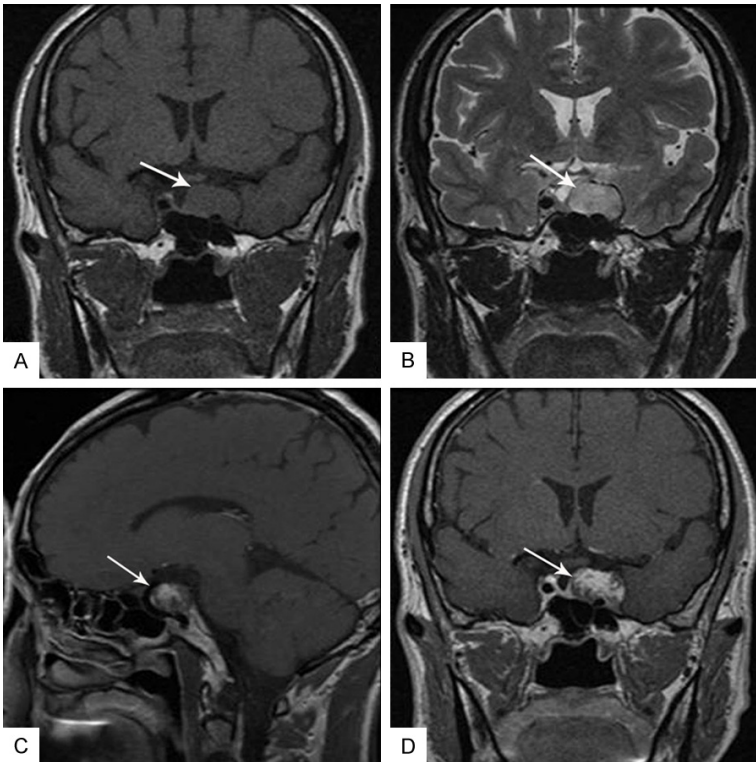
The mass (arrow) was homogeneous iso-signal on T1-weighted MRI (A) and heterogeneous hyper-signal on T2-weighted MRI (B). With gadolinium contrast (C, D), the mass was obviously unevenly and partially enhanced, progressively from the central region to the peripheral region, with linear and curvilinear areas interspersing throughout the tumors, and the peripheral region of the lesion was hardly enhanced.
